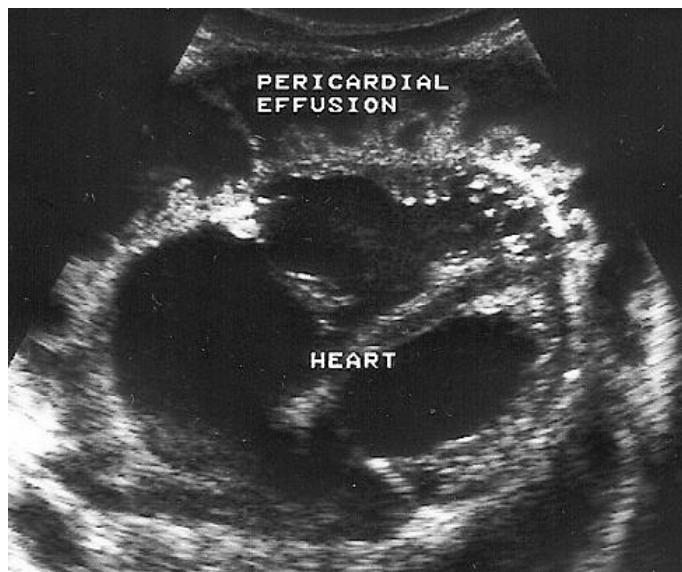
B-mode echocardiograph (cardiac ultrasound) showing pericardial effusion around the heart (Dark areas surrounding the heart).
